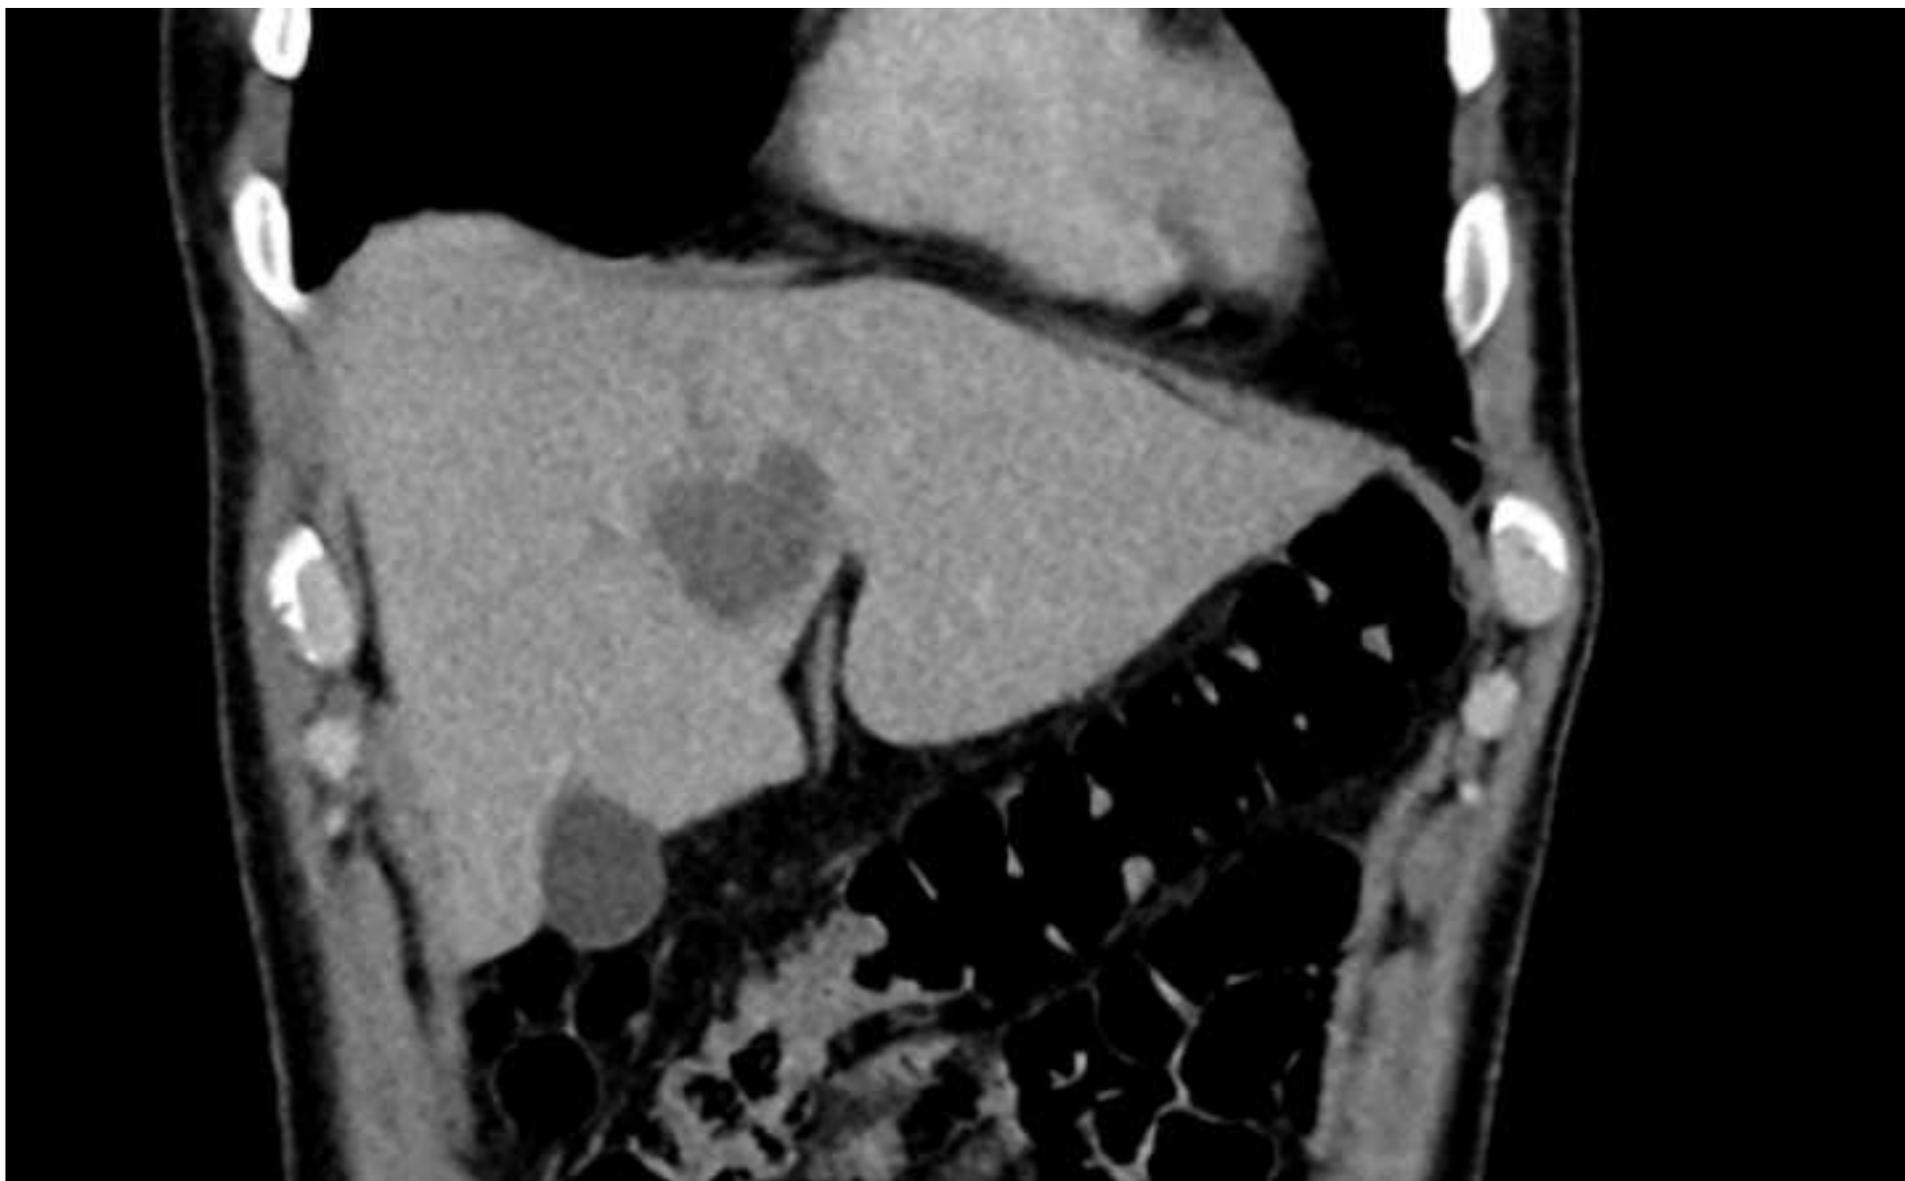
Coronal CT image of liver abscess
